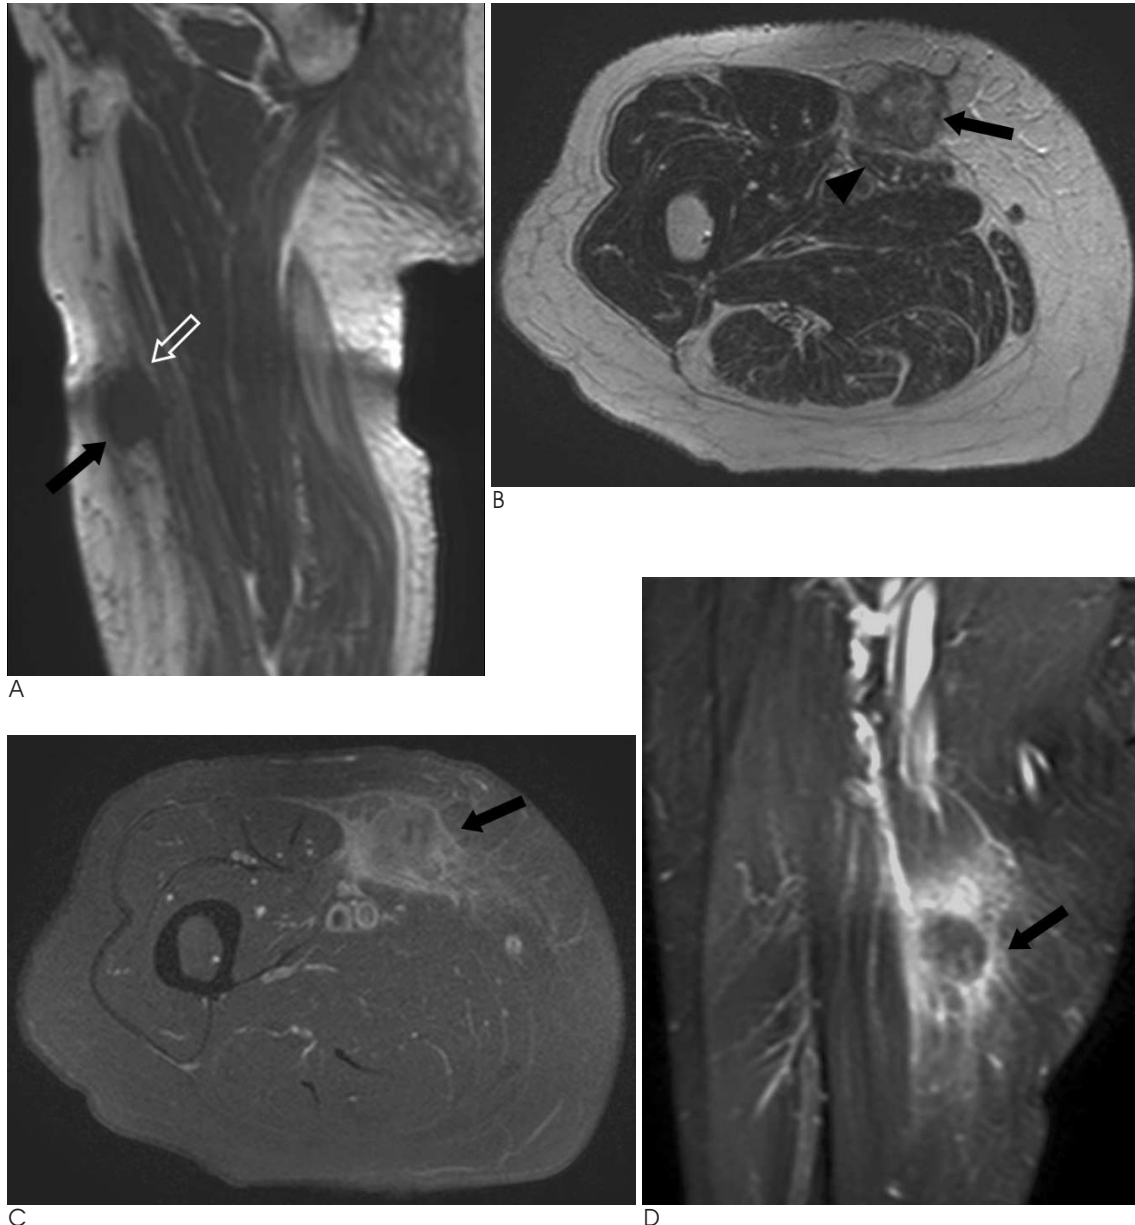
A. A sagittal T1-weighted spin-echo MR image shows a round, partially ill-margined hypointense mass (arrow) in the right thigh. Note the focal fascial thickening (open arrow) that is visualized at the interface between the mass and the sartorius muscle. B. An axial T2-weighted MR image shows the mass (arrow) is located mainly within the subcutaneous fatty tissue with heterogeneous intermediate to high signal intensity. Note the indistinct interface between the mass and compressed sartorius muscle (arrowhead). C. On an axial GD-DTPA-enhanced MR image, the mass (arrow) is enhanced heterogeneously and has a focal poor enhancing area related with tumor necrosis in the center of the mass. Focal enhancement of the fascial plane of the sartorius muscle indicates invasion. D. On a coronal GD-DTPA-enhanced MR image, adjacent soft tissue is strongly enhanced including the fascial plane; the enhancement is probably related to peritumoral edema and invasion. Note the mass (arrow) with a lobulated border, central necrosis and relatively extensive peritumoral enhancement.
